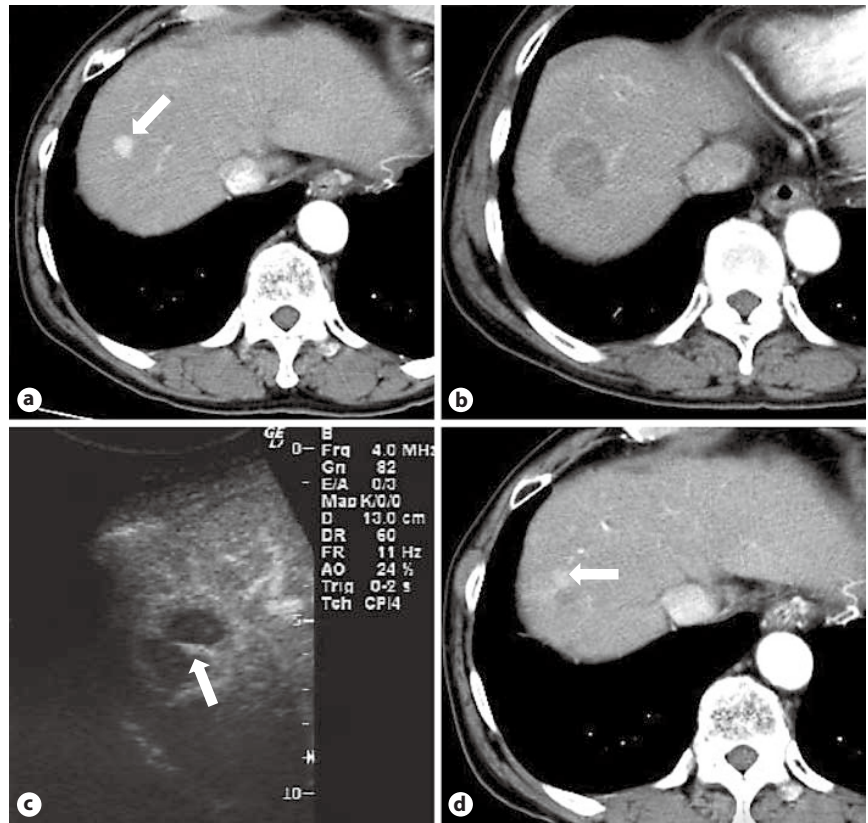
Case presentation of local tumor recurrence after RFA. a A 62-year-old man with a 1.3-cm HCC; Dynamic CT shows a hypervascular tumor (arrow) in segment VIII; RFA was performed on 25th July, 2007. b On dynamic CT, the effect of RFA was judged as complete response with a safety margin >5 mm (CRSM+). c By using a defect reperfusion test in Kupffer phase, there was a vessel in the ablated area (arrow); the judgment by CEUS was complete response without a safety ablative margin (CRSM-). d Local tumor recurrence was observed on 4th June 2008 (arrow).
